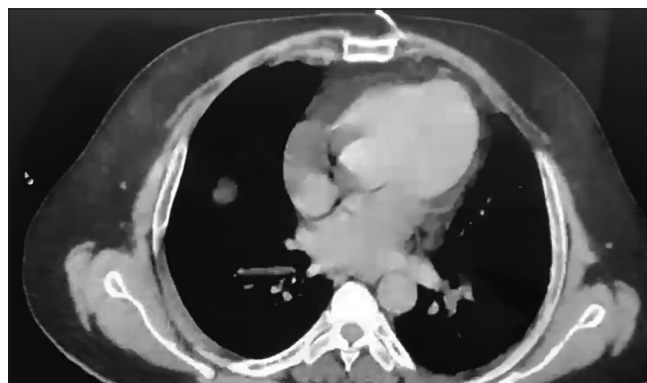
CT scan chest is clear of any pathology
